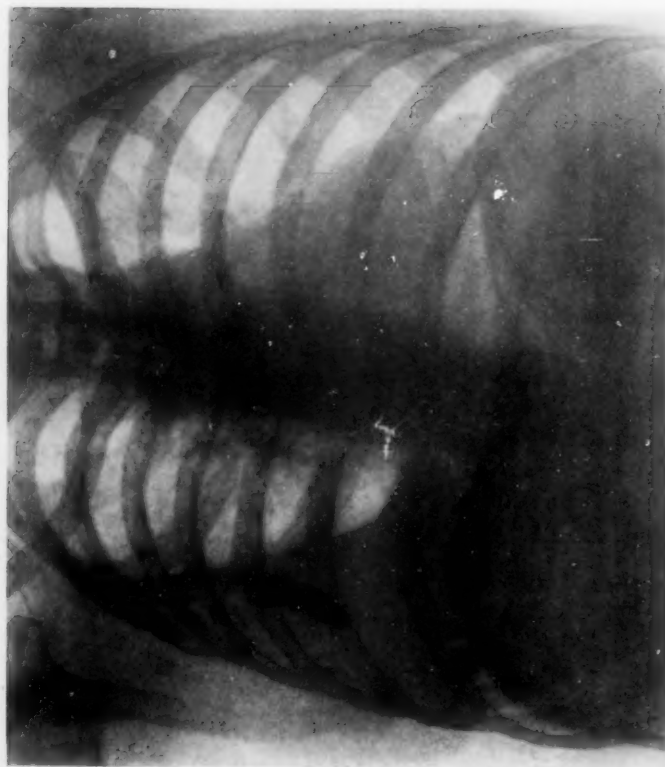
A chronic empyemic cavity treated by mobilization and excision of the parietal pleura followed by irrigations of the extrapleural cavity with Dakin's solution. (See text, Method 3.) The small dense shadow is the remains of the bismuth paste injected to determine the form and position of the cavity. (X-ray taken before operation.)
